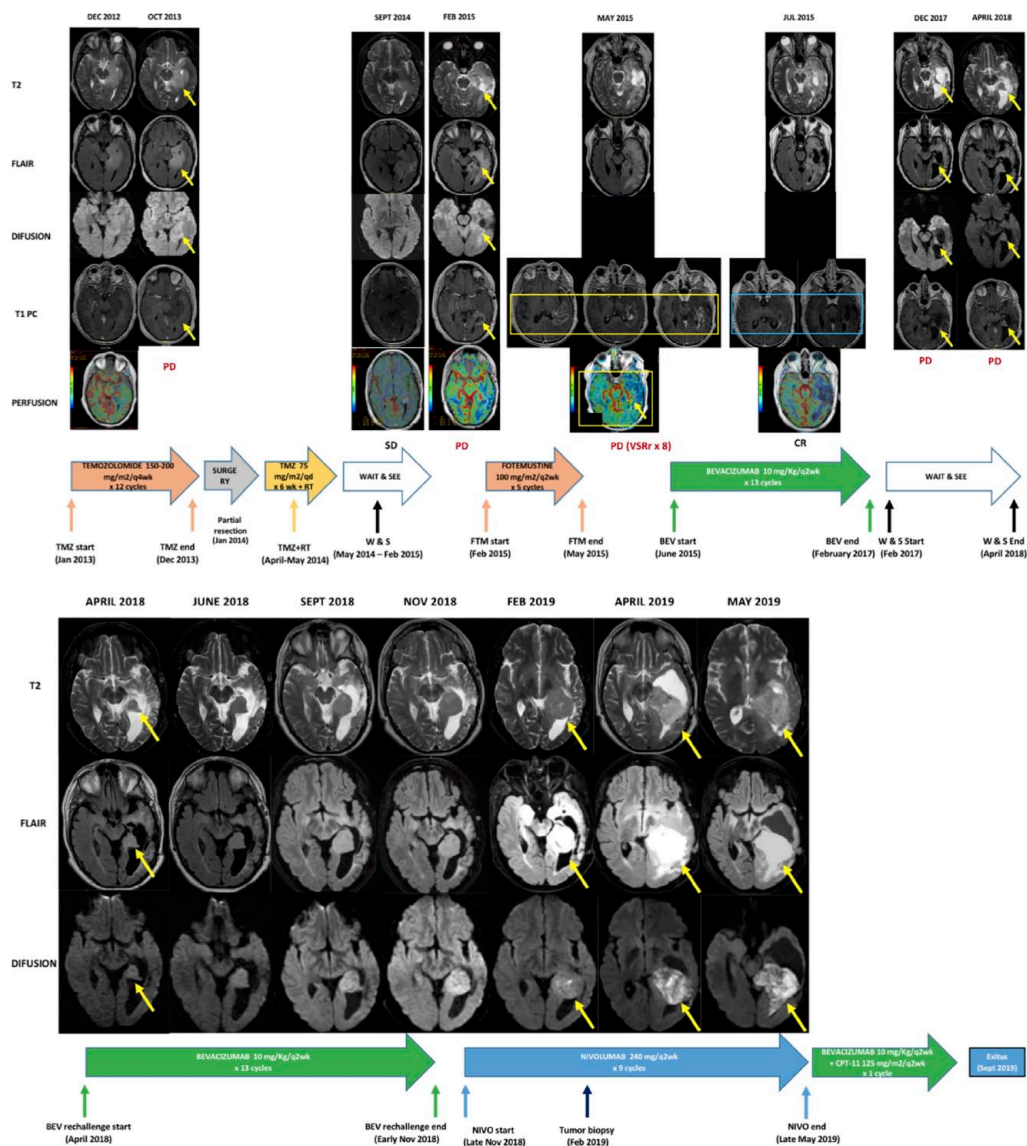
MRI tumor evolution from initial diagnosis until the end of therapy.
